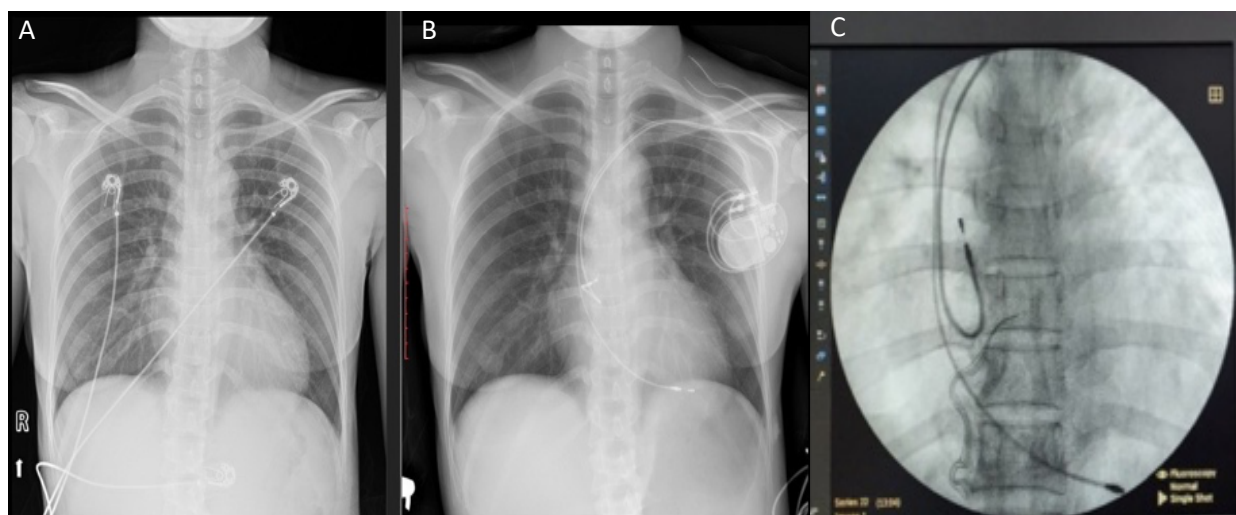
A. Pre-operative Chest Xray PA : No significant lung findings, B. Post-operative Chest Xray PA : With dual chamber pacemaker device inserted, C. Intra-operative TEE : Dual Chamber Device
